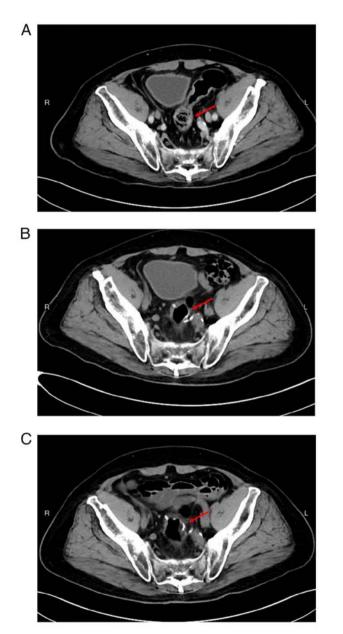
Abdominal CT images, with the red arrows indicating the tumor or surgical bed region. (A) After radiotherapy, before surgery, (B) 6 months after surgery and (C) nearly 1 year after surgery.
